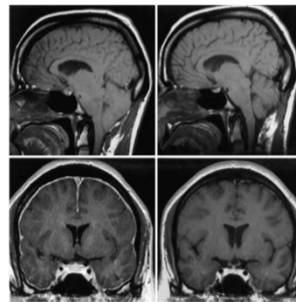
Upper Left and Right: Sagittal T₁-weighted magnetic resonance (MR) images revealing caudal displacement of the cerebellum, distortion of the craniomedullary junction, and effacement of the preponine and perichiasmatic cisterns preoperatively (upper left) and significant elevation of the cerebellar tonsils, restoration of the cisterns, and almost complete normalization of the cerebral displacement postoperatively (upper right). Lower Left and Right: Coronal gadolinium-enhanced T₁-weighted MR images showing intense meningeal enhancement, bowing of the optic chiasm over the pituitary fossa, and reduction of the perichiasmatic cisterns preoperatively (lower left) and almost complete resolution of the meningeal enhancement and restoration of the crowding of the optic chiasm postoperatively (lower right).
